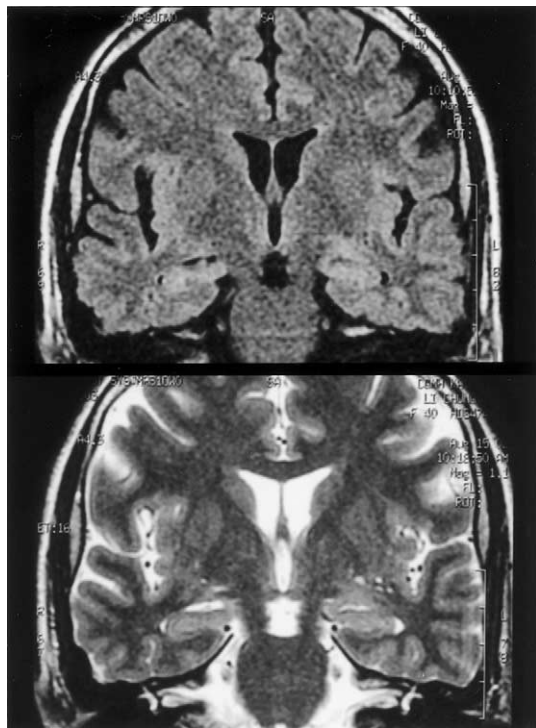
Brain MRI, coronal view of T1- and T2-weighted images, reveals right hippocampal atrophy.
